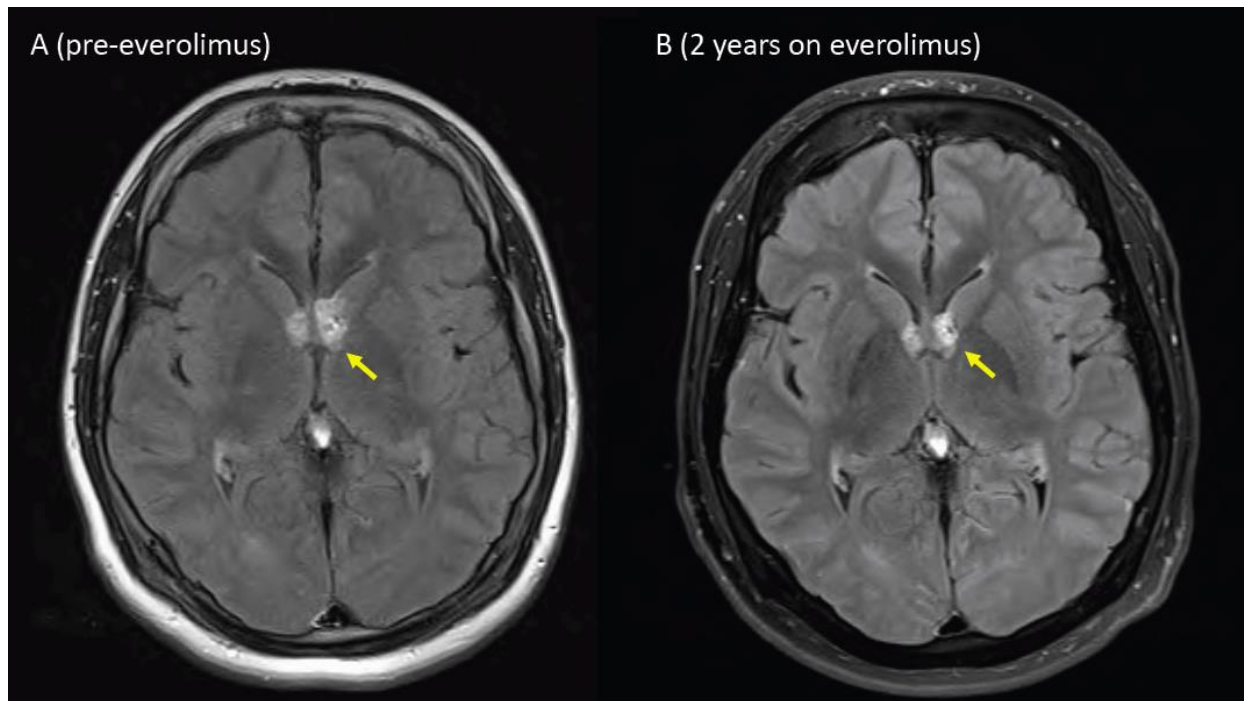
MRI brain of TSC patient treated with everolimus for subependymal giant-cell astrocytoma.
